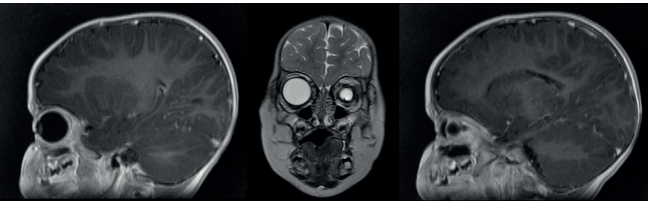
The magnetic resonance imaging of the orbital cavities. The uninterrupted trajectory of the optic nerve and unaffected optic chiasm, along with left eyeball aplasia and a persistent hyperplastic primary vitreous in the left eye (linear, with less signal strength tissue approx. 2 mm long), treated with epikeratoprosthesis
